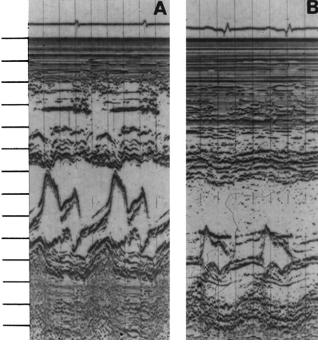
A, Mitral valve M-mode of a normal subject. B, Mitral valve M-mode recording of a patient with a dilated left ventricle, reduced mitral flow, reduced ejection fraction, and elevated LV end-diastolic pressure. (From Feigenbaum H. Echocardiography. 1st ed. Philadelphia, PA: Lea and Febiger; 1972.)
